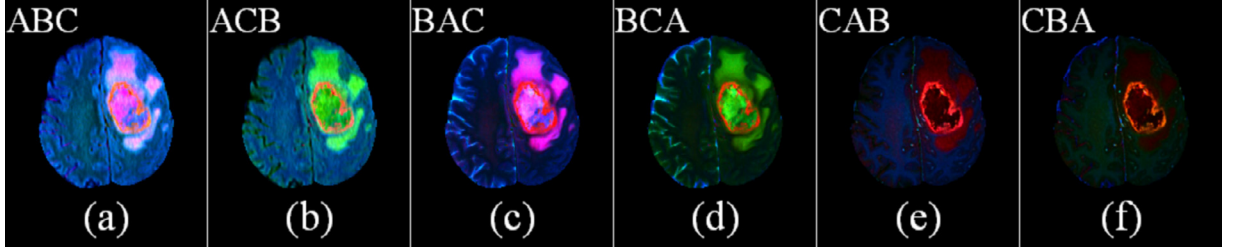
Six corresponding pseudo-colored ($L^*a^*b^*$) converted brain MR image sequences. (For interpretation of the references to colour in this figure legend, the reader is referred to the web version of this article.)
